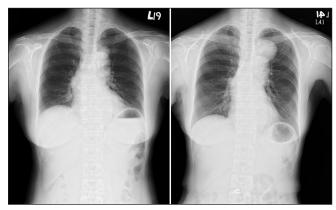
(a) The chest plain film revealed a tumor mass about 3 cm above the aortic arch. (b) The chest X-ray was taken about 11 months later which was showed an enlarged tumor mass
